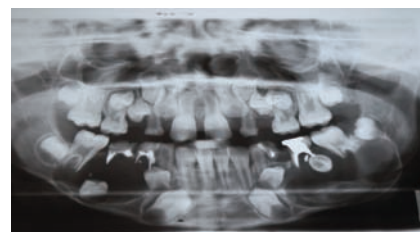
Panoramic radiograph showed bilateral pericoronal radiolucencies.
